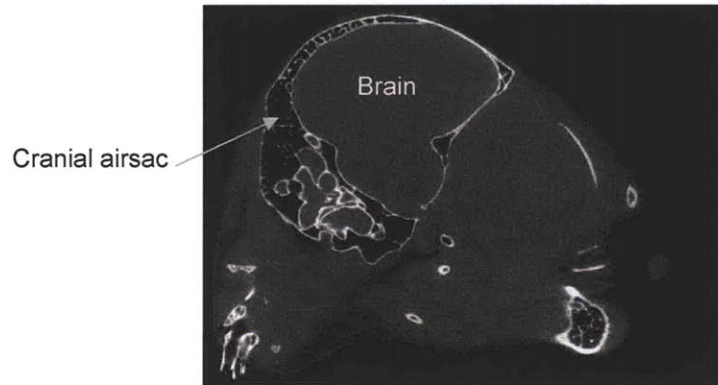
Disruptive auditory feedback system. (A) Photographs of speaker implant. A hearing-aid speaker generated broadband noise to distort the auditory feedback of the bird during singing. The sound was delivered through a speaker tube into the cranial airsac. Song was recorded using a miniature microphone attached to the side of the implant. (B) The cranial airsac as seen in a parasagittal CT-section through the middle ear. This airsac is continuous with the inner surface of both eardrums.
